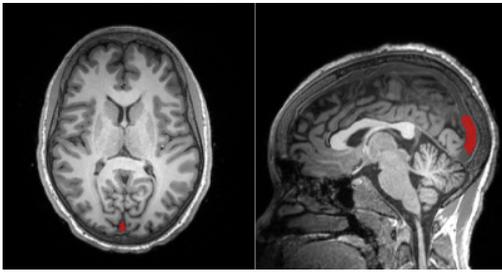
Axial and sagittal views of a T1-weighted image from a representative SCA subject with the superior sagittal sinus region of interest overlaid in red.
